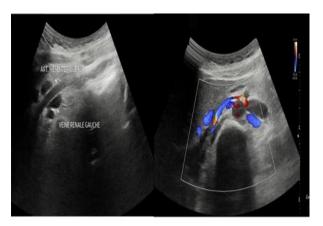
Renal doppler ultrasound showing dilatation of renal vein
